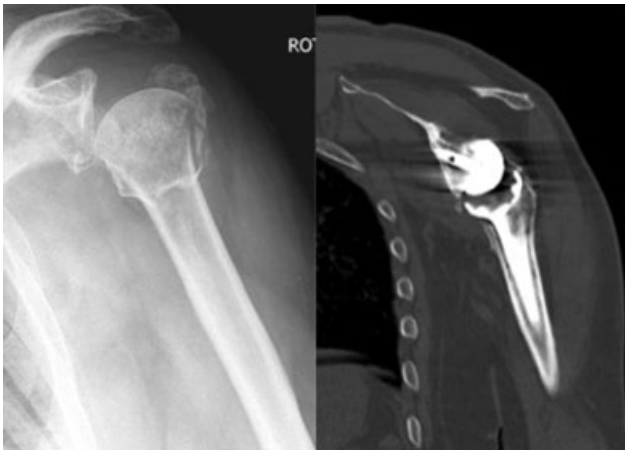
Computed tomography demonstrating tuberosity healing.
